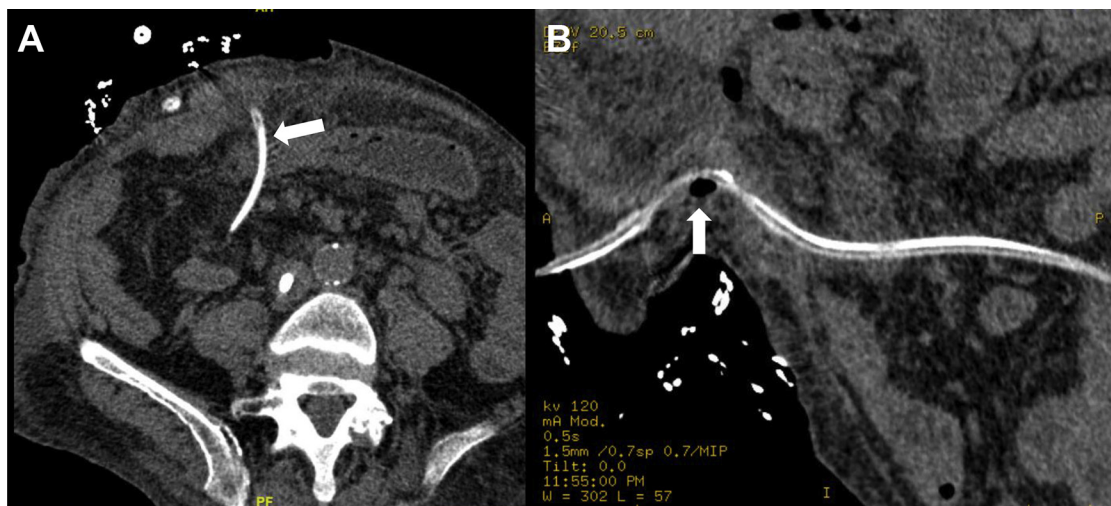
Computed tomographic images show the catheter perforating the wall of the transverse colon. (A) Coronal section: transcolonic passage of the catheter (arrow). (B) Sagittal section: catheter passing through the wall of the bowel (arrow).
